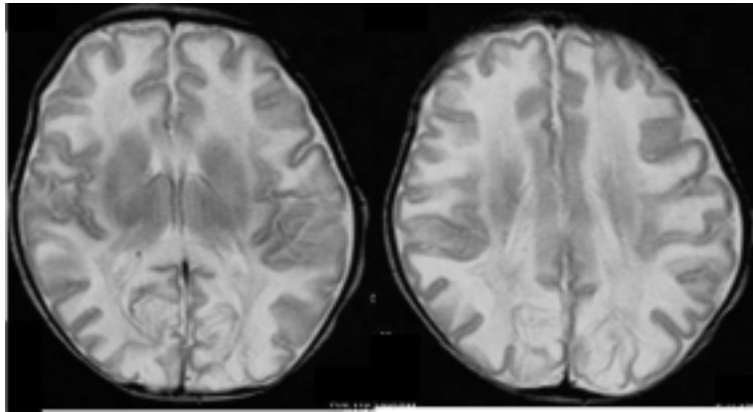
T2-weighted magnetic resonance imaging on postnatal day 17 showing an accompanying lesion in the occipital lobe.
